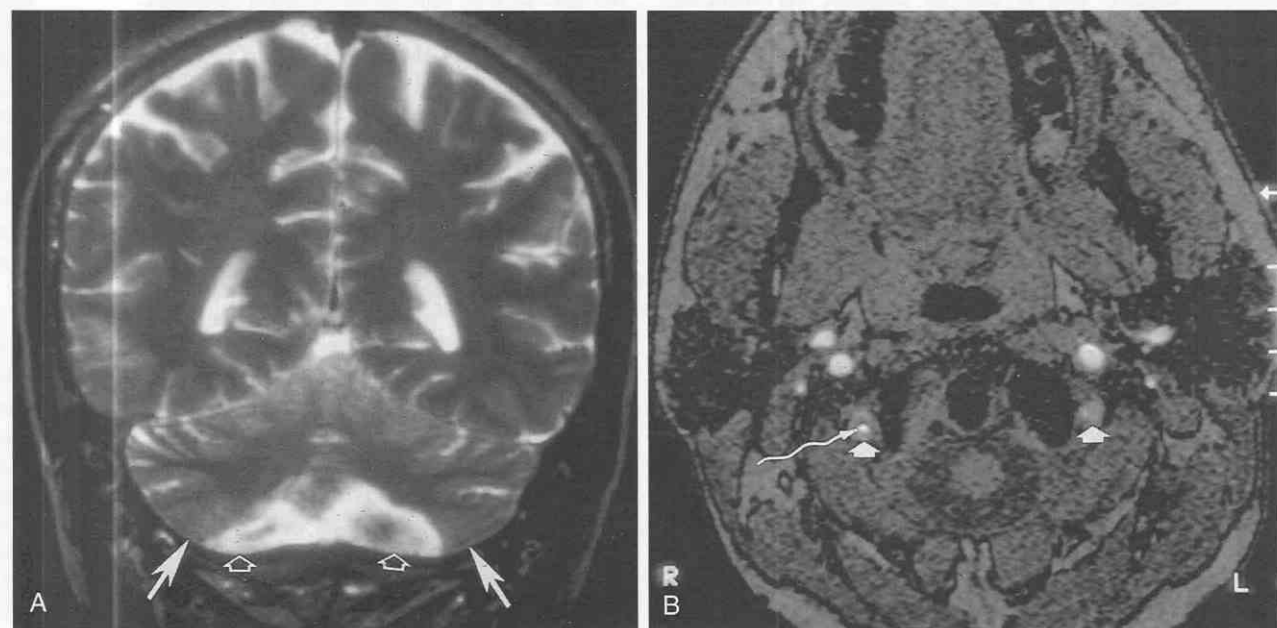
Bilateral stroke of the posterior inferior cerebellar artery (PICA). A, T2-weighted coronal MR image shows high signal in the territories of this artery bilaterally (*open arrows*). The territories of the anterior inferior cerebellar arteries are spared (*arrows*). B, Axial source image from a 2D time-of-flight MRA study shows diminished signal within both vertebral arteries (*short arrows*). A small channel of flow is present in the right vertebral artery (*long wavy arrow*). The findings are those of bilateral vertebral artery thrombosis.
